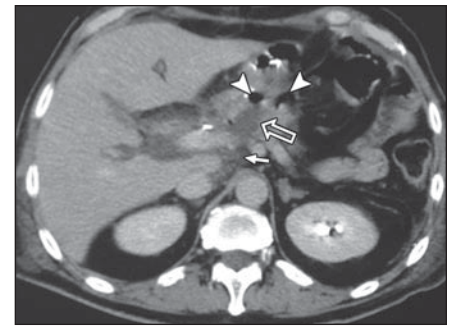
62-year-old man 7 days after pancreaticoduodenectomy for pancreatic adenocarcinoma. Transverse contrast-enhanced helical CT scan of abdomen shows perianastomotic fluid collection (open arrow) close to anastomosis and containing small air bubbles (arrowheads). Solid arrow indicates another collection in posterior compartment of superior recess of lesser sac. Drainage tube (not shown) was displaced far from anastomosis in abdominal cavity. On postoperative day 7 patient had no clinicobiologic findings of pancreatic fistula, but both radiologists made correct diagnosis of pancreatic fistula (occult pancreatic fistula). During hospital stay, amylase level became elevated; therefore, patient had diagnosis of pancreatic fistula at hospital discharge.
